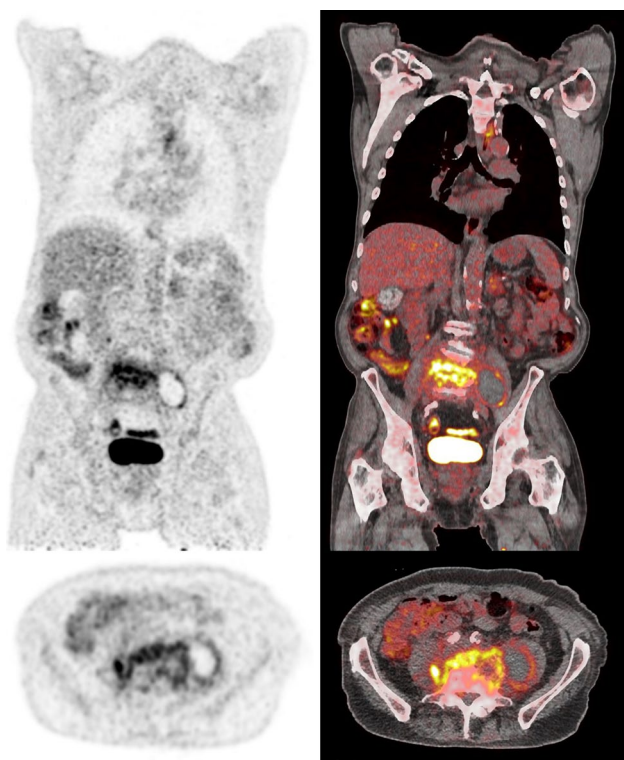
Spondylodiscitis with psoas abscess. A 69-year old man with a history of diabetes mellitus, alcohol abuse and recent cholangitis requiring endoscopic retrograde cholangiopancreatography (ERCP), complicated by sepsis. [^{18}F]FDG PET/CT demonstrates spondylodiscitis at level L4-L5 extending into the left psoas muscle with a large photopenic area, suggestive of abscess. Culture of CT-guided aspiration of the psoas abscess was positive for *E. coli*
